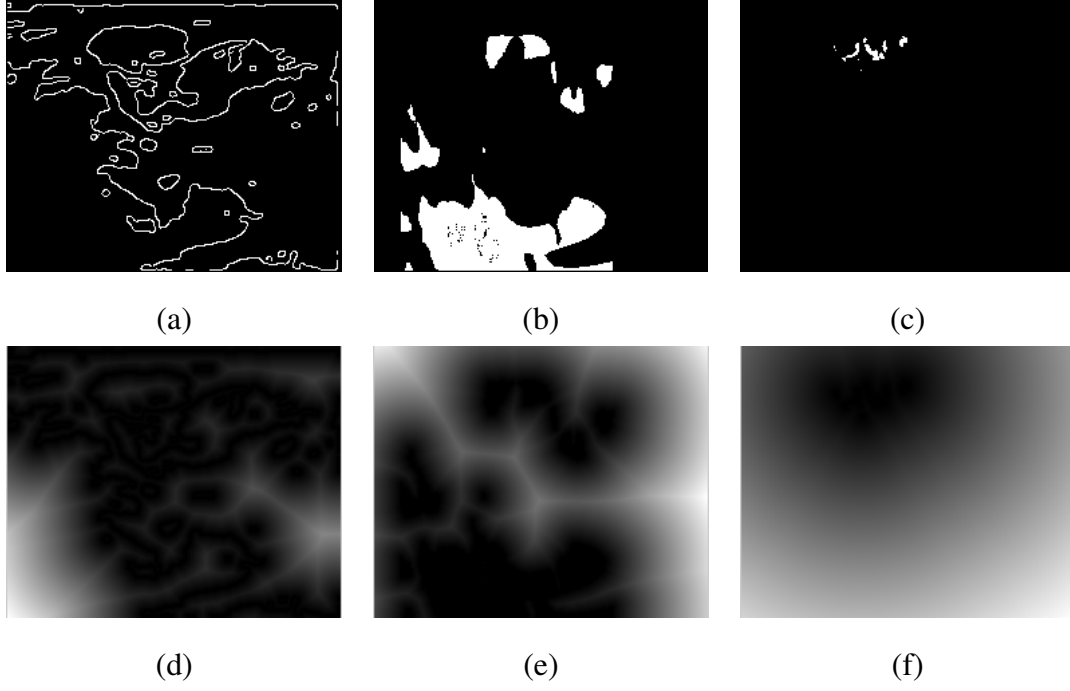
The results of Euclidean distance transform of (a) Edge Map, (b) Binarized Elastography, and (c) Binarized Power Doppler, are shown in (d)-(f) respectively.
